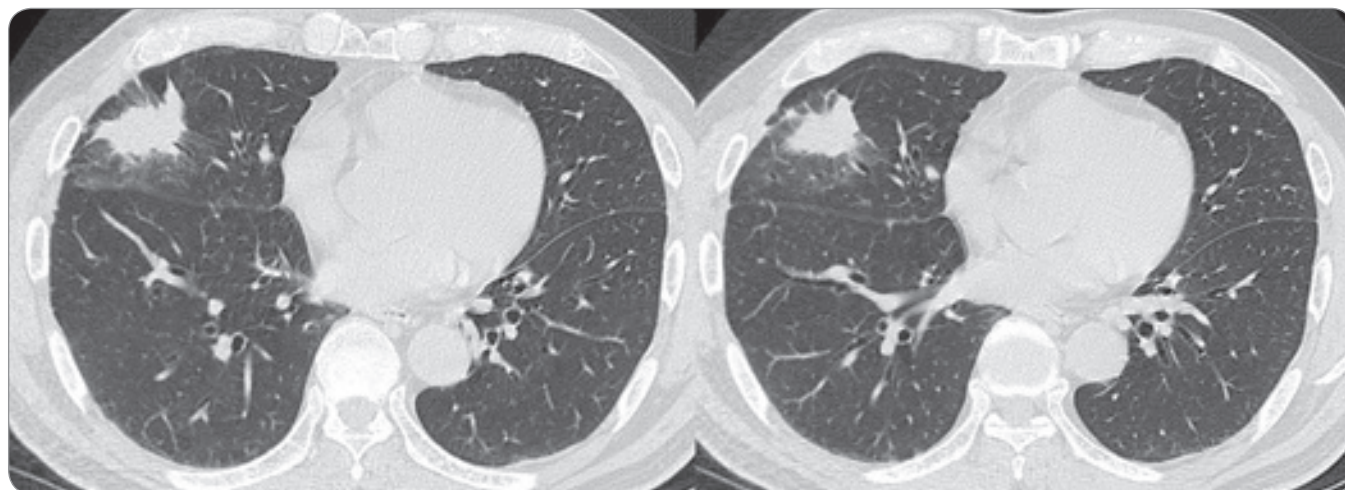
A chest CT on admission revealed a 35 × 24 mm mass in the middle lobe of the right lung.
